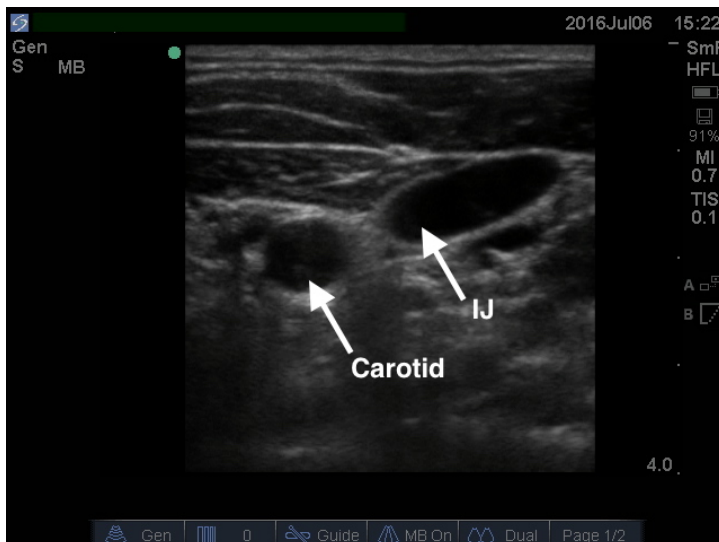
Transverse ultrasound of the major neck vessels.
